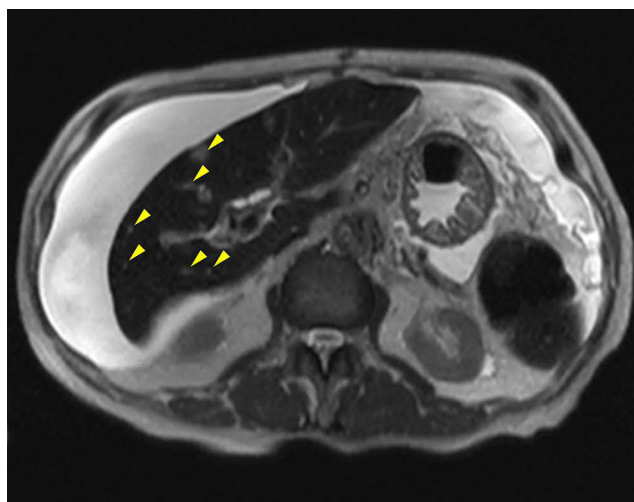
MRI follow-up 7 months postoperatively (the end of April, 2025). Findings indicate negative dynamics due to multiple focal liver lesions, most likely metastatic (mts, shown by yellow pointers). Significant ascites persists.
